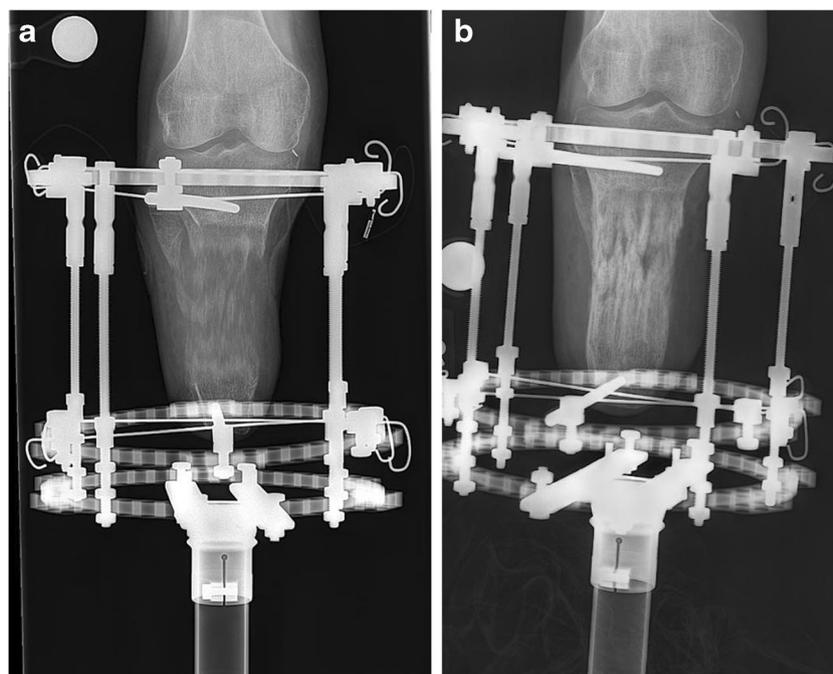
a AP radiograph at 6 months after surgery showing distraction gap. b AP radiograph at 12 months after surgery showing union of the 8-cm regenerate. Frame removal was done shortly after this.
